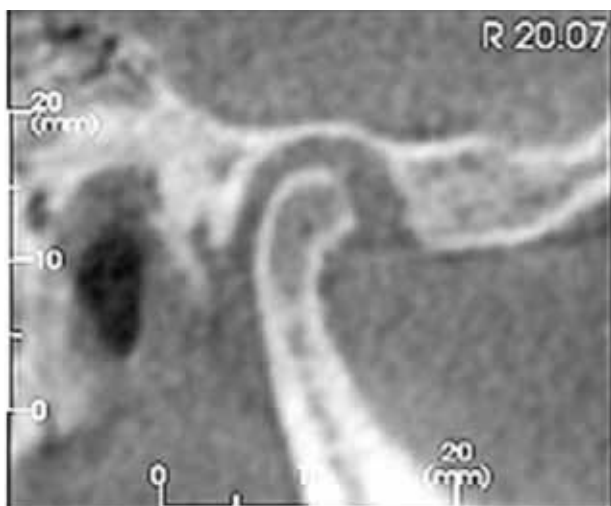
CBCT image of a TMJ patient's research.
